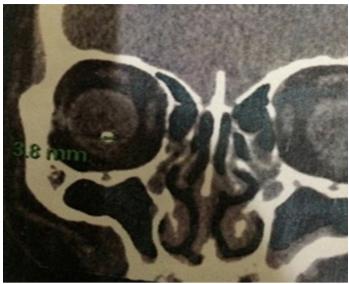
CT scan showing RIOFB
